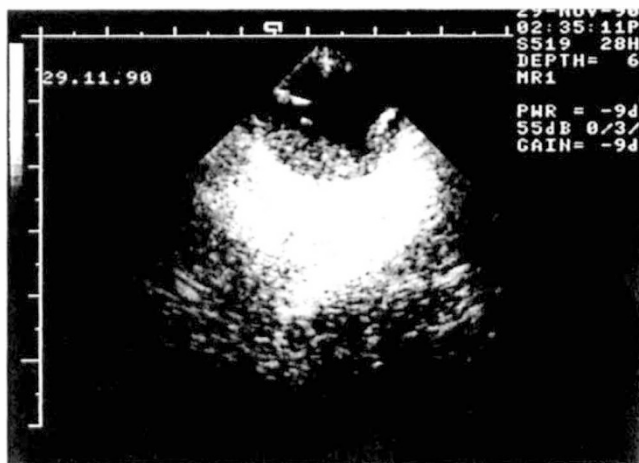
Ultrasonogram giving the appearance of an intraocular malignant melanoma with associated detachment of the retina.
